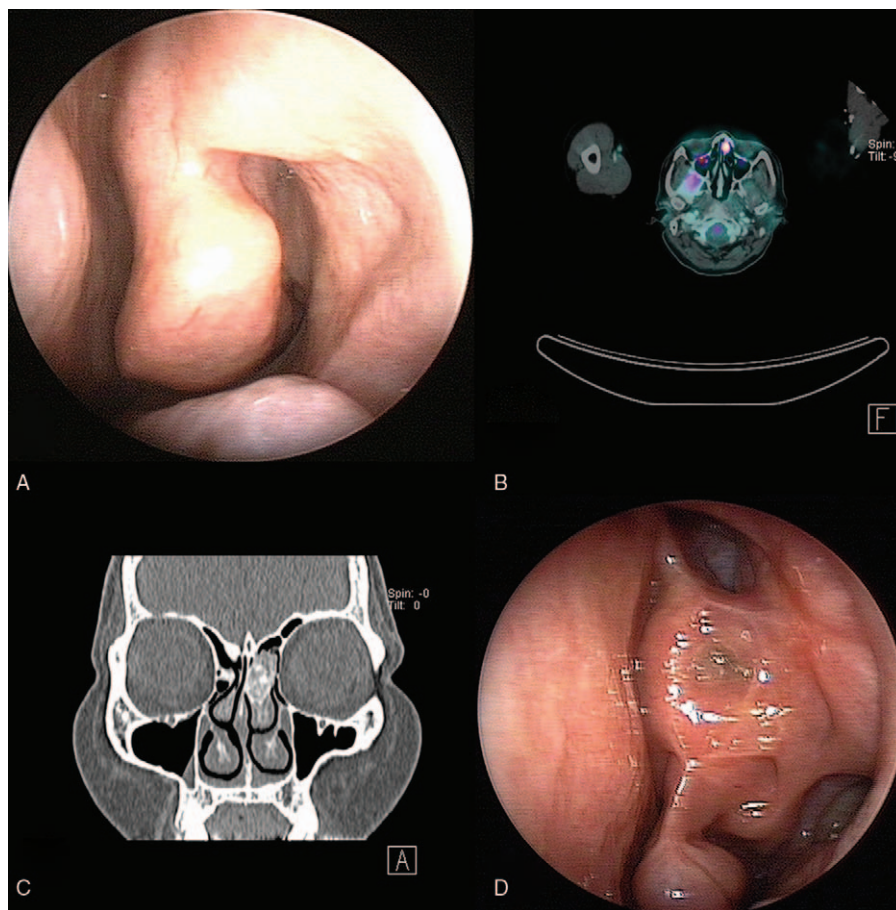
A, Endoscopic view of the left nasal cavity in our second case. B, PET CT revealed a hypermetabolic mass in the left middle turbinate [maximum standardized uptake value (SUV)=9.72] showing no invasion of the adjacent structures. C, Paranasal coronal CT showed a $1.0 \times 1.2 \times 1.9$ cm, heterogenous calcified mass in the left middle turbinate. D, 7-year follow-up endoscopy showed no recurrence.
